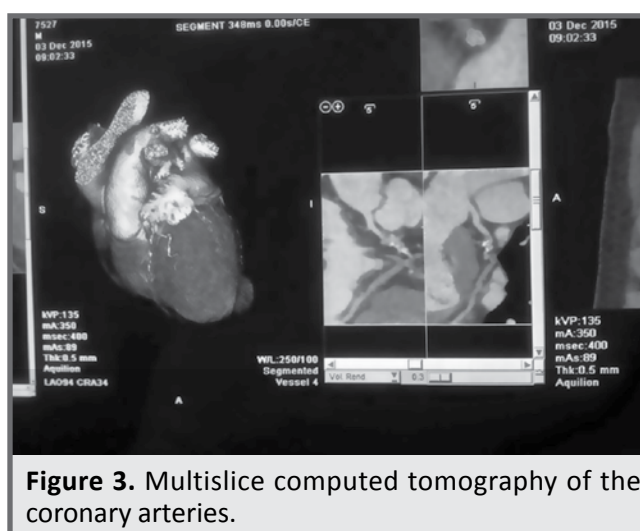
Multislice computed tomography of the coronary arteries.
